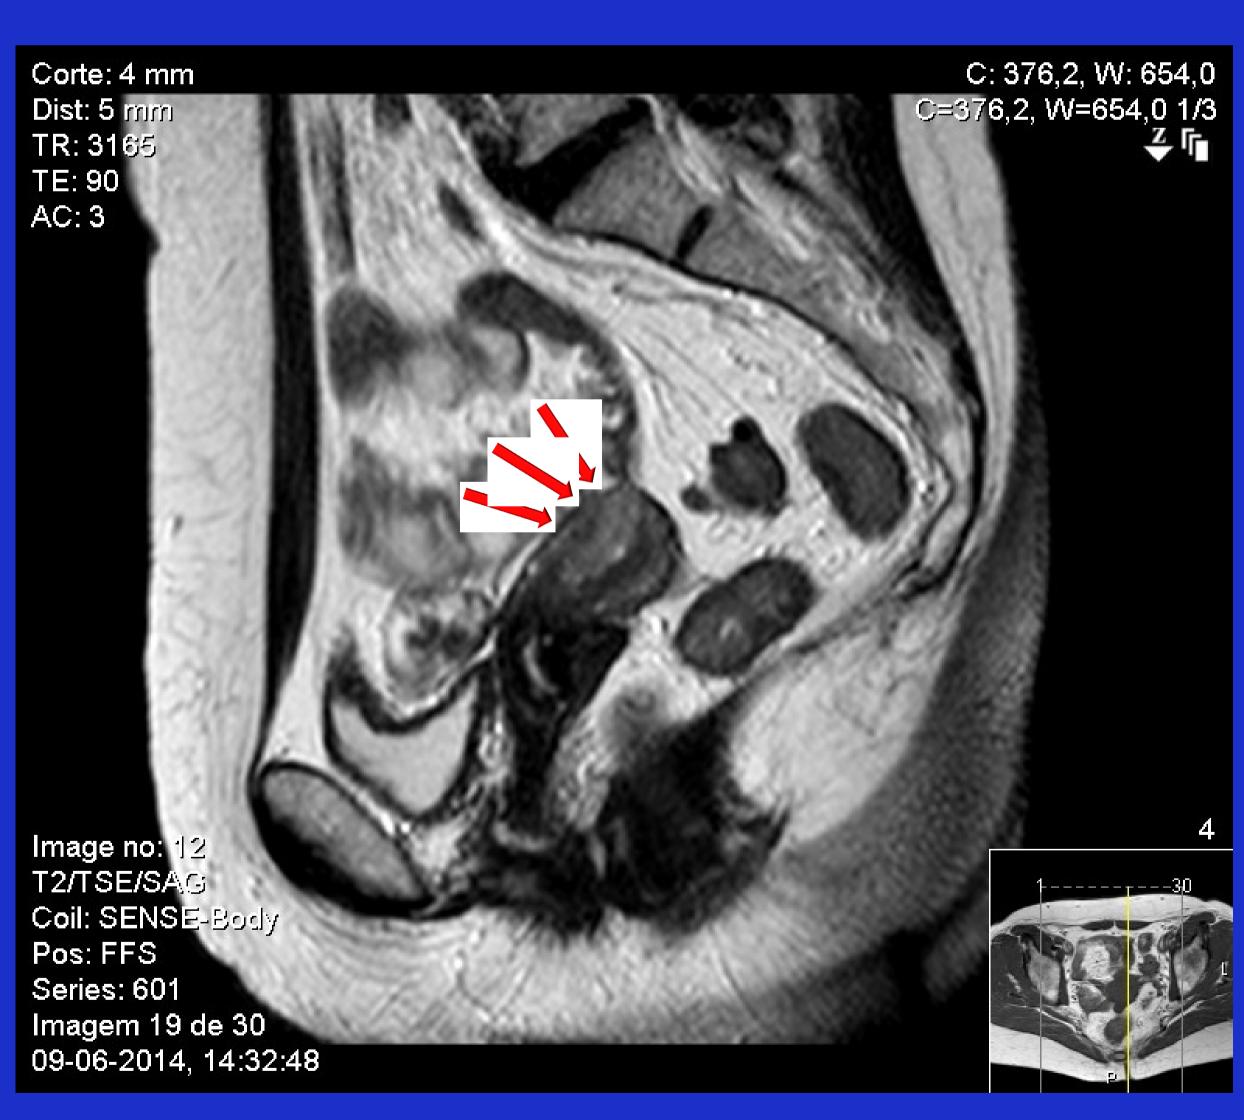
Pelvic MRI in a sagittal plan presenting a high signal intensity endometrial lesion extending to the external half of the fundal anterior wall of the myometrium.
